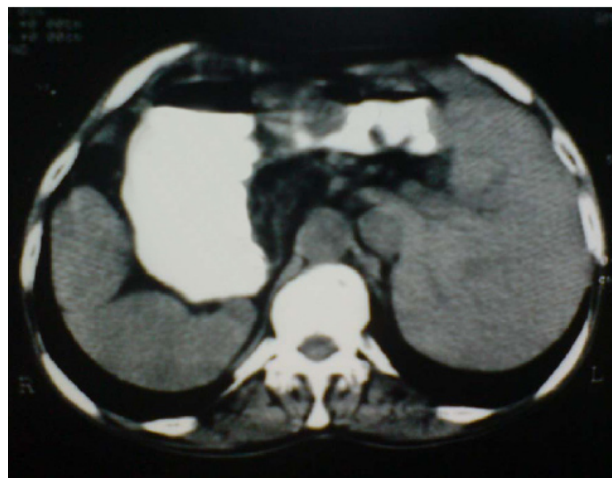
Computed tomography showing inversion of abdominal viscera (situs inversus), liver on left and lobulated spleen on right, and antrum lesion.
